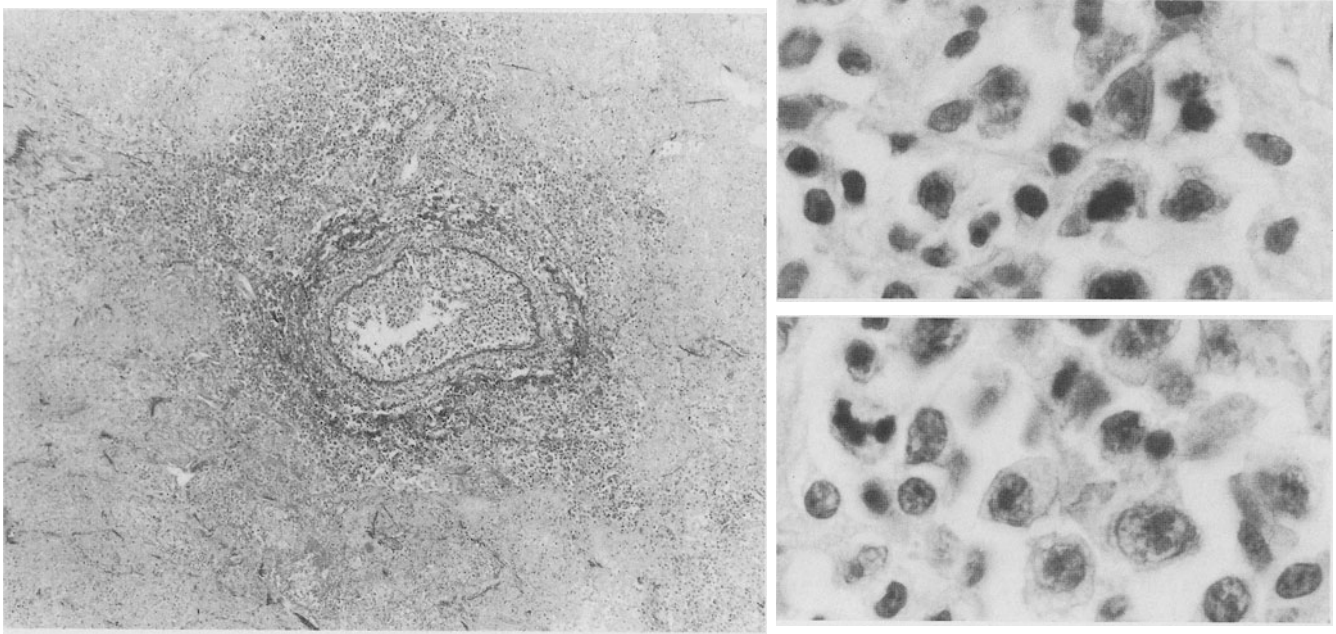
Large cell lymphoma presenting as multiple nodules on chest radiograph. Prominent vascular infiltration is surrounded by tumor necrosis (left). The vascular infiltrate (upper right) is mixed in composition but includes atypical
